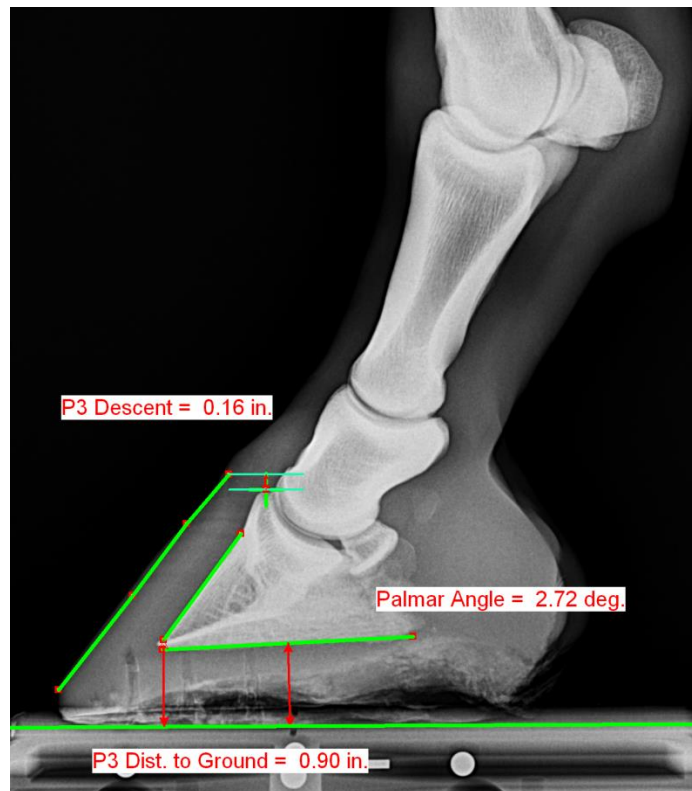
A preventative radiograph can be a great aid to hoof care. Better yet, a radiograph which has been accurately measured as in this example. The 'Palmar Angle' is an important measurement which gives the angle formed between the ground and the underside of the pedal bone. My rule of thumb is that it should be in between 1.5 degrees and 6.0 degrees. The 'P3 Descent' measures how far the pedal bone is falling below the top of the hairline – this is ideally a small value – less than half an inch for an average sized hoof. Radiographs also help the farrier assess the thickness of the sole – in this image the 'P3 Distance to Ground' give a measurement of sole thickness at the tip of the pedal bone. Ideally this value is greater than half an inch for an average sized hoof.
